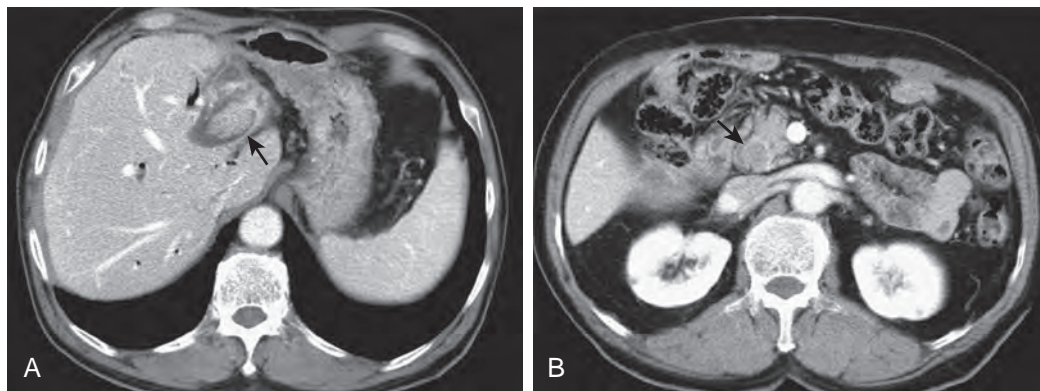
Multiple bile duct adenomas. A. Contrast-enhanced axial CT scan shows an intraluminal polypoid tumor (arrow) with homogeneous enhancement in dilated left intrahepatic bile duct. B. CT scan caudal to A demonstrates similar intraductal mass (arrow) in the common bile duct.
